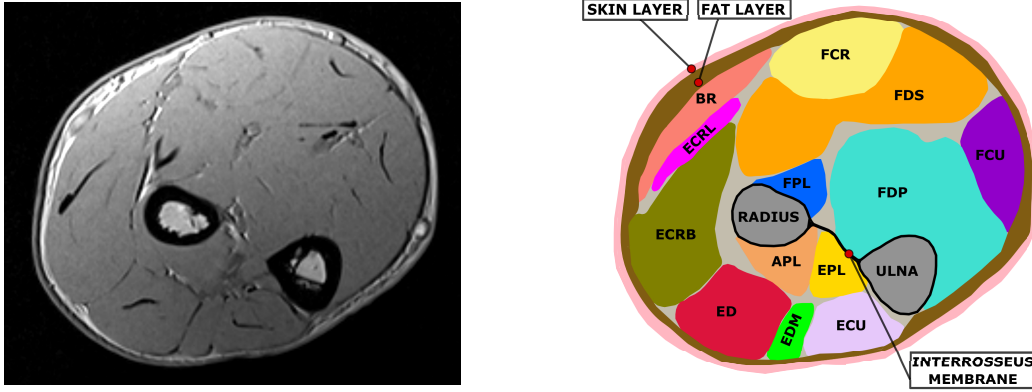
Example of segmentation on an MRI slice. On the left the original MRI is depicted, on the right its segmentation is reported. Muscles are represented with different colors, the radius and ulna bones are reported in gray. It is possible to observe the interosseus membrane connecting ulna and radius and dividing the posterior and the anterior side muscles. Skin and fat layers are colored respectively in pink and brown.
